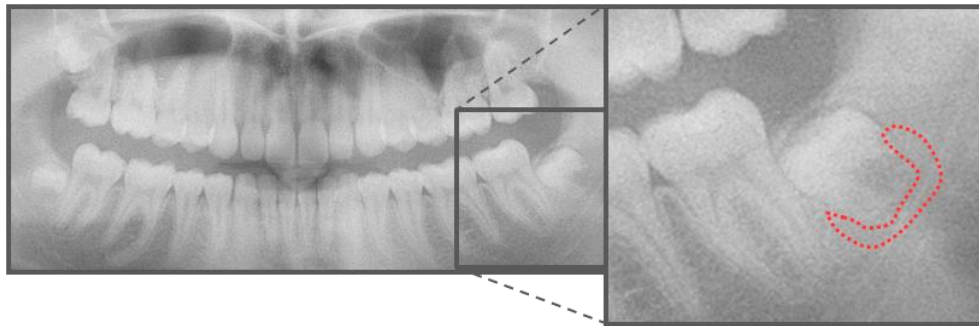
Panoramic radiograph of a 17 years old patient showing wisdom tooth follicle.
